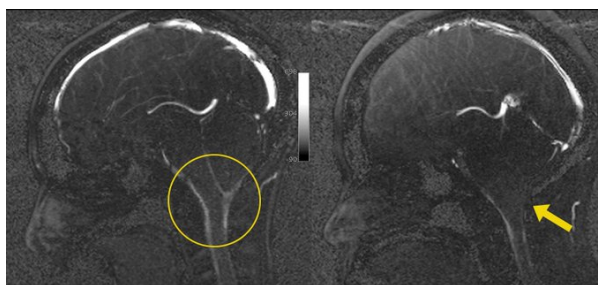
Cine-flow MRI. A normal flow cine MRI in the left and blocked CSF flow in the right. Extracted from (24).
